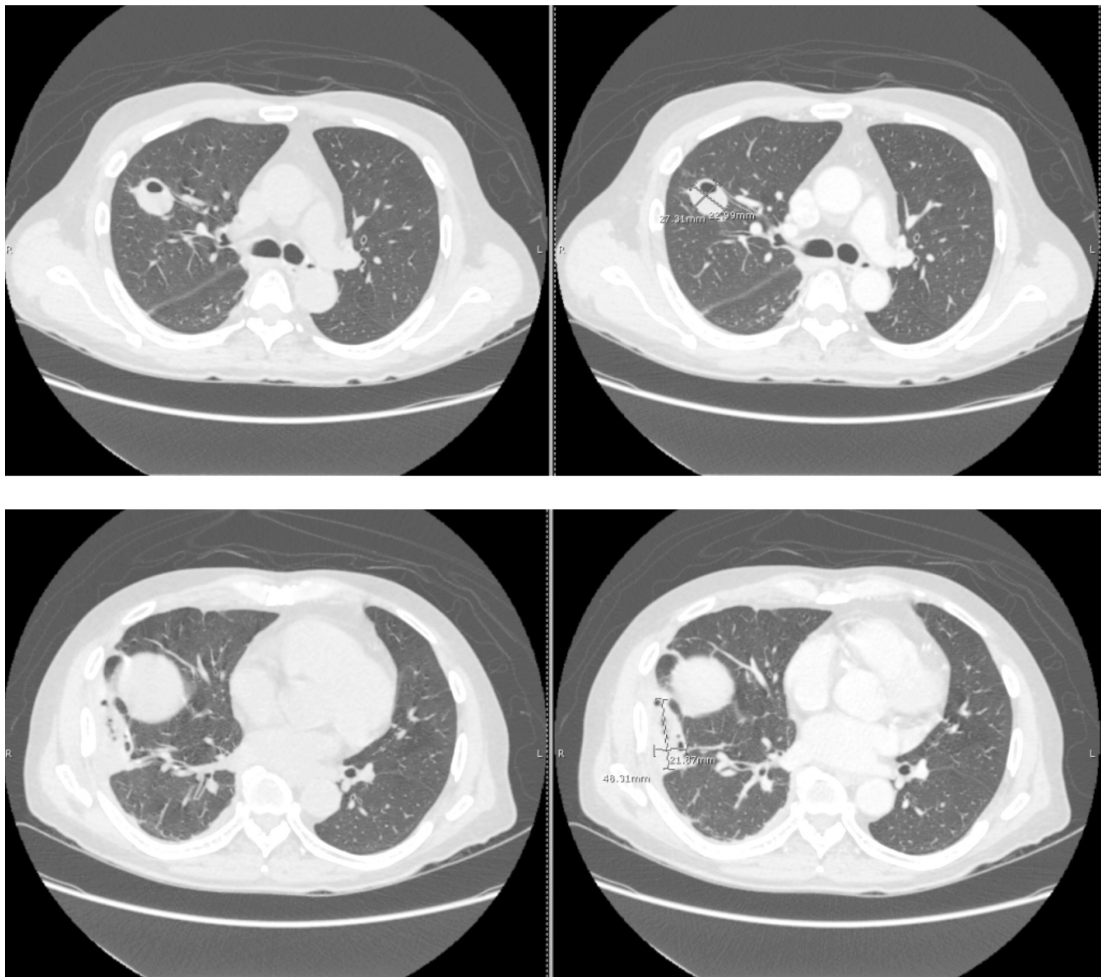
Axial contrast enhanced computed tomography (CT) scan, lung window view scan of the chest showing two cavitary lesions in the anterior segment of the right upper lobe and anterior basal segment of the right lower lobe of the lungs showing an air-fluid level and rim enhancement, measuring about 2.7 x 2.3 cm and 4.8 x 2.2 cm, respectively. Minimal pleural effusion in the right lung and multiple lymphadenopathies in the right hilum are also noted.
